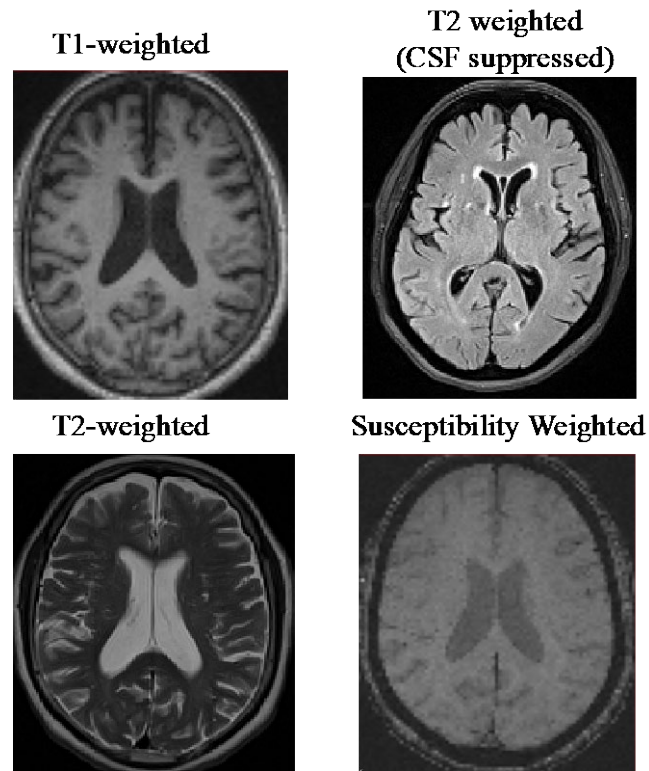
MR image showing a single axial section for T1-weighted, T2-weighted, T2-weighted (CSF suppressed) and Susceptibility weighted imaging
